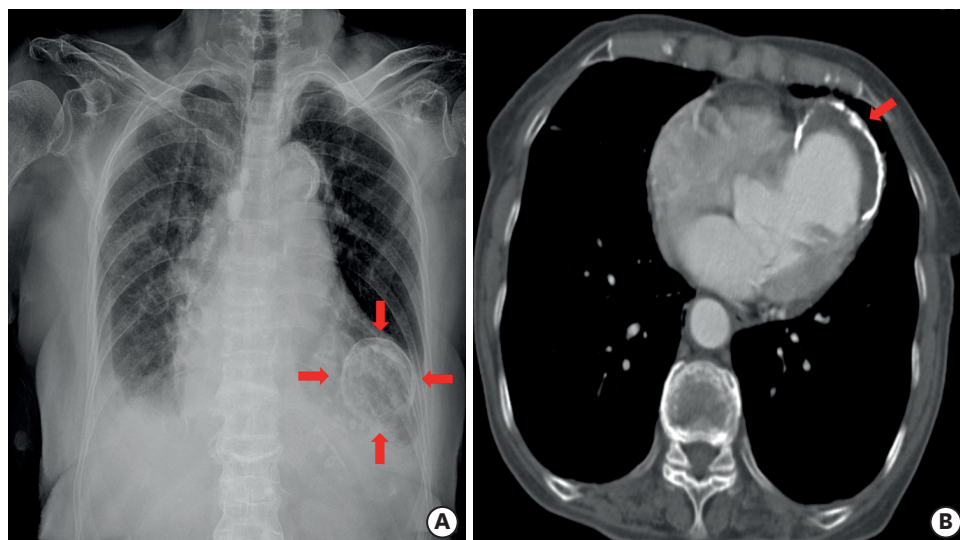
Radiographic images. (A) Chest X-ray showed a large, well-demarcated, spherical calcified mass (red arrows) at LV. (B) Chest computed tomography demonstrated an extensive myocardial calcification (red arrow) along with the aneurysm of LV. LV = left ventricle.
